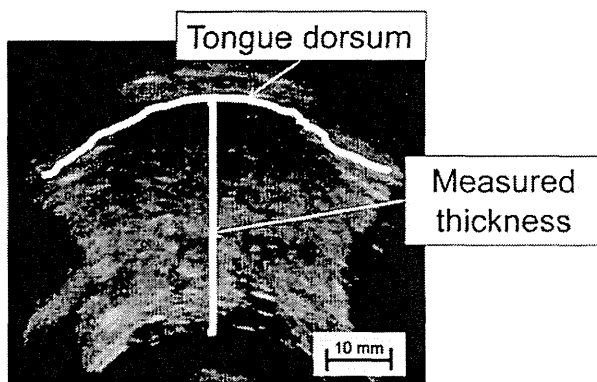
Ultrasonographic image
